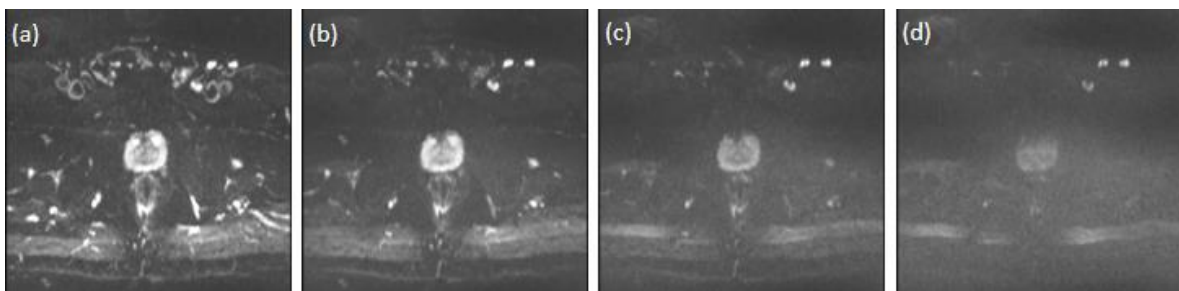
Example of DWI data of the prostate at  $b$ -values: 0 (a), 150 (b), 500 (c) and 1000  $\text{s.m}^{-2}$  (d).
